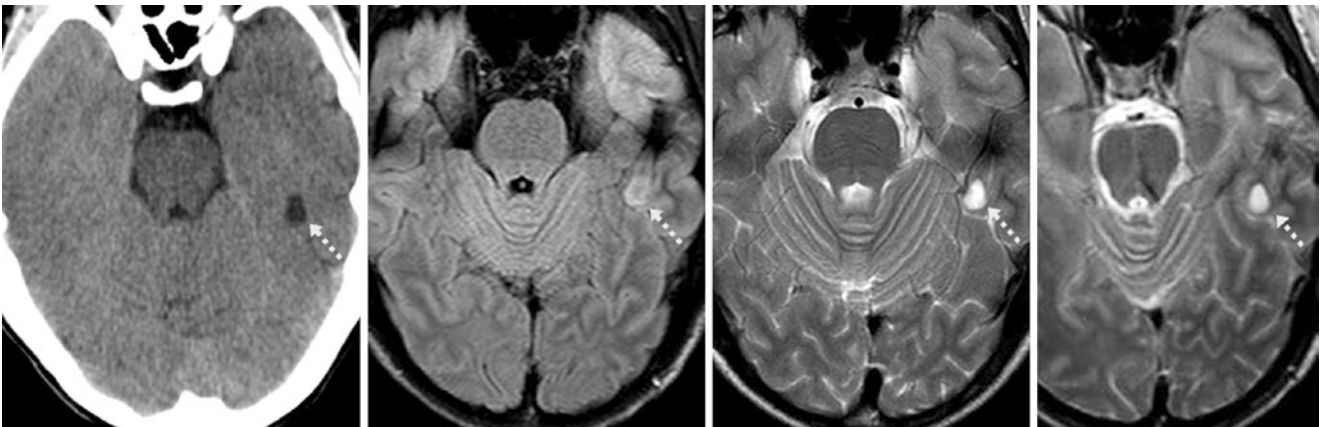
Comparison case of dysembryoplastic neuroepithelial tumor (DNET). A 21 year old with seizures had a left temporal hypodensity (*dotted arrows*) on NECT (*left*) thought to be a PVS versus a low-grade cystic neoplasm. Axial FLAIR (*left middle*) and T2WI
